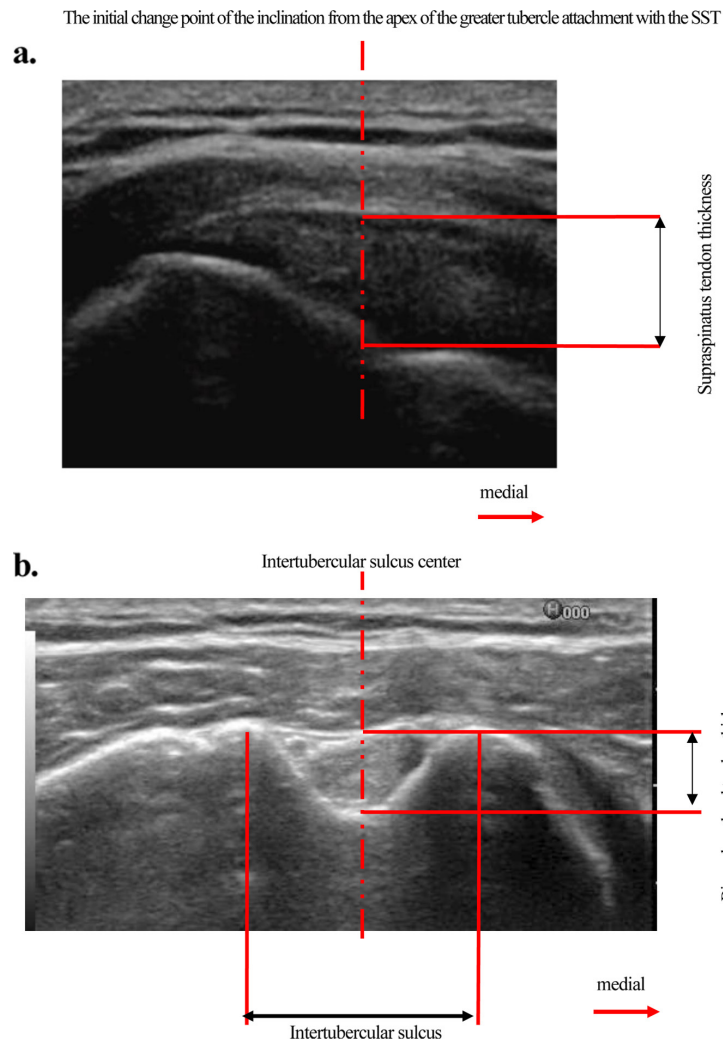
Ultrasound measurement of thickness. a. Measurements of the thickness (black arrows between the red sections) of the supraspinatus tendon (SST); b. Measurement of the thickness (black arrows between the red sections) of the biceps long head tendon.
